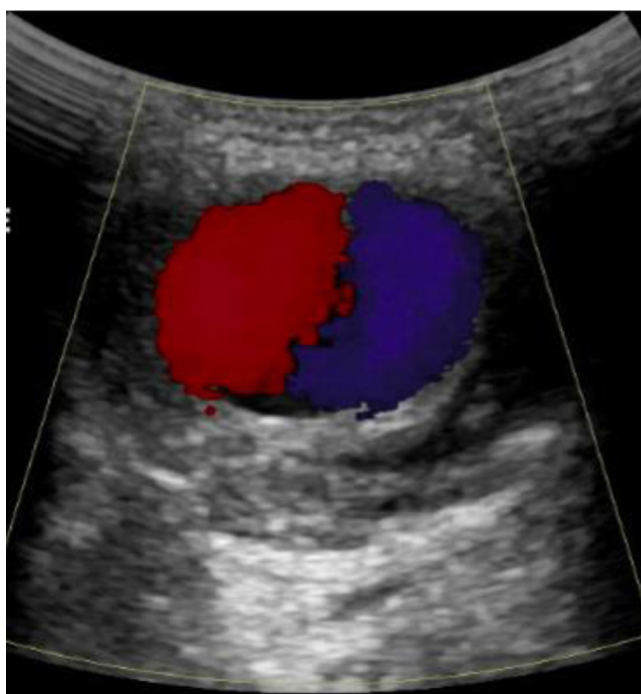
Color Doppler sonogram showing a typical “yin-yang” sign of the to-and-fro turbulent arterial flow in the pseudoaneurysm of the inferior lateral geniculate artery of the right knee.
